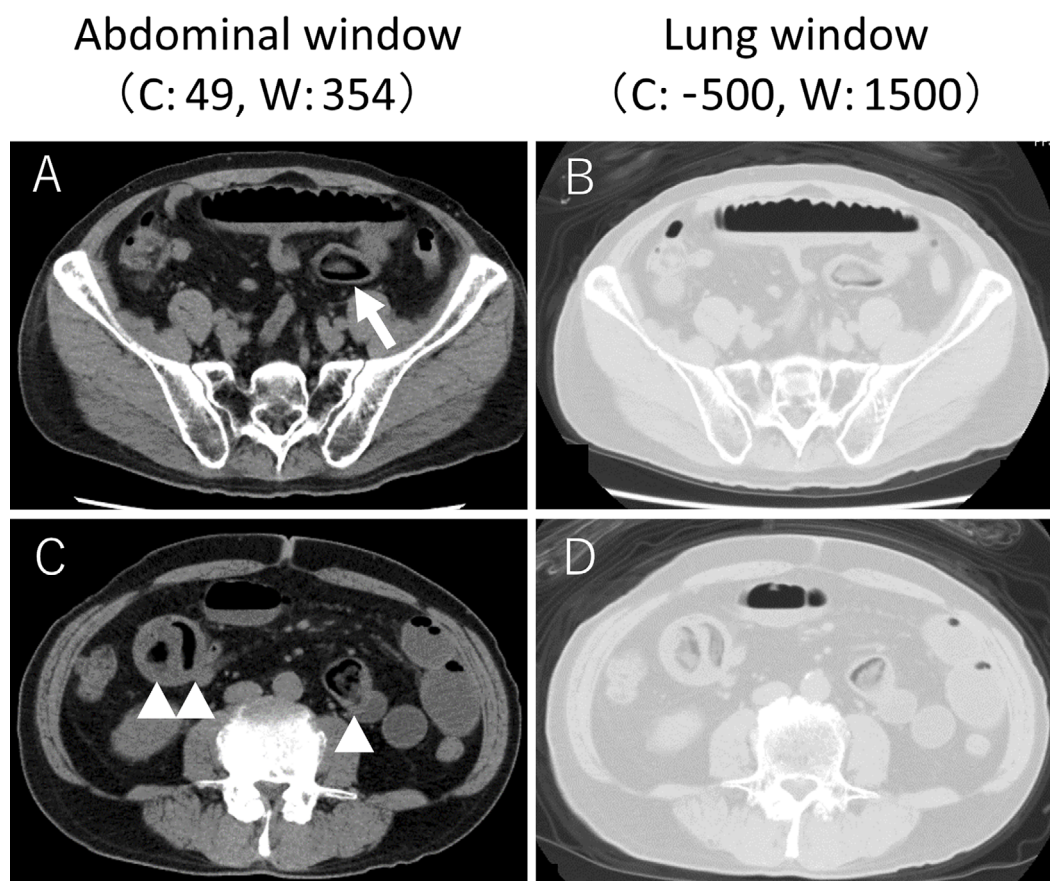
Computed tomography findings of the abdomen. (A) A ring-shaped foreign body is identified at the proximal area of the transition point in the ileum (arrow). (B) The foreign body is easily distinguishable from bowel gas on the lung window setting. (C) Three other ring-shaped or crescent-shaped objects are found in the proximal ileum (arrowheads). (D) These objects have the same features as the foreign body in (B) on the lung window setting.
